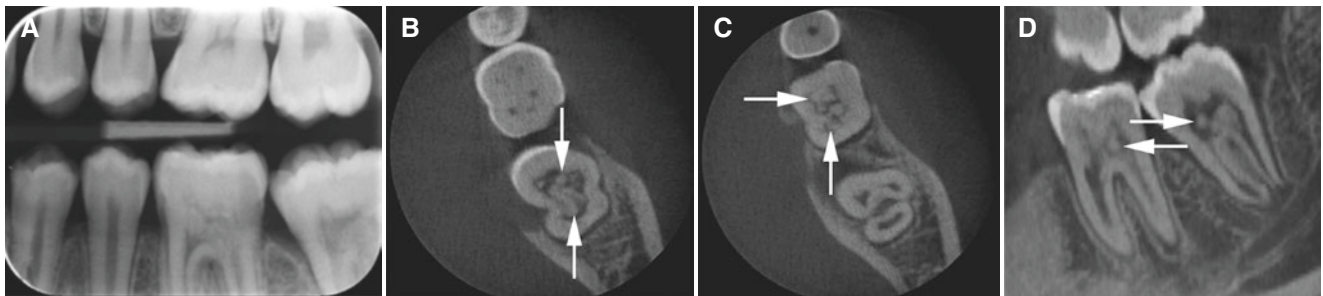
Pulp stones, mandible; 15-year-old male. (A) Intraoral view shows pulp chamber radiopacities in mandibular molar teeth. (B, C) Axial and (D) oblique sagittal CBCT images show multiple
